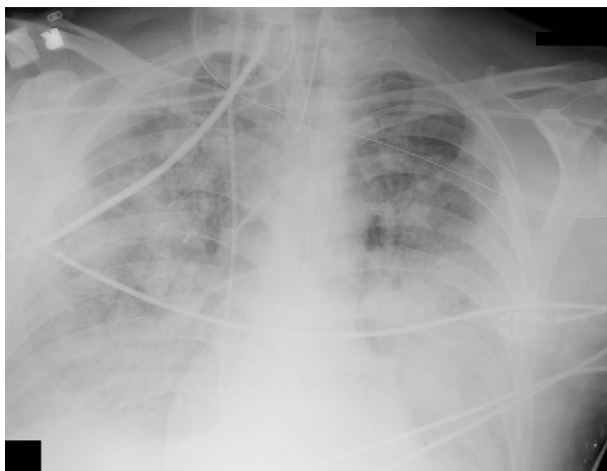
Chest radiograph revealing pulmonary edema prior to phentolamine infusion.
